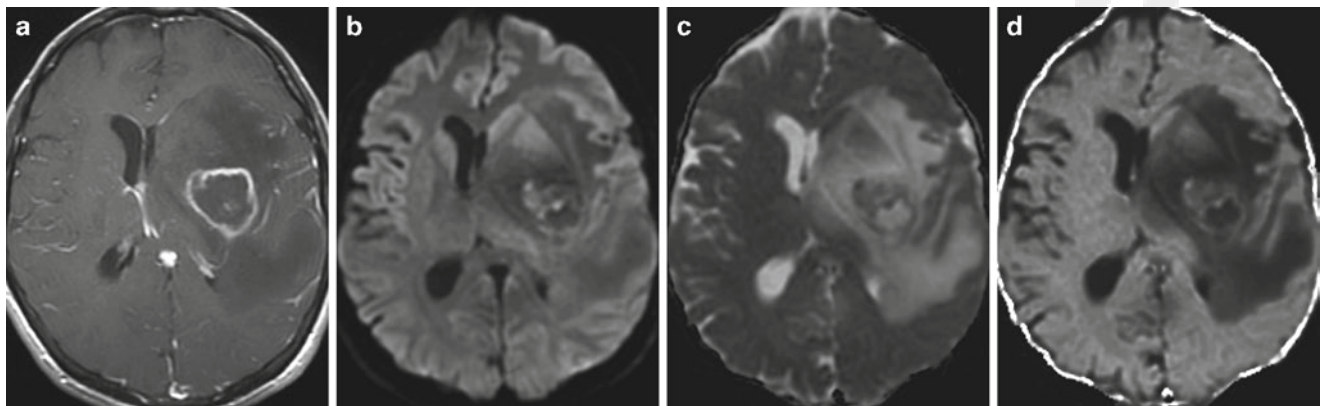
Toxoplasma abscess. (a) Axial contrast-enhanced T1, (b) DWI, (c) ADC, and (d) exponential images demonstrate a ring enhancing lesion centered in the posterior putamen with associated vasogenic edema and mass effect. On diffusion maps, the lesion is
